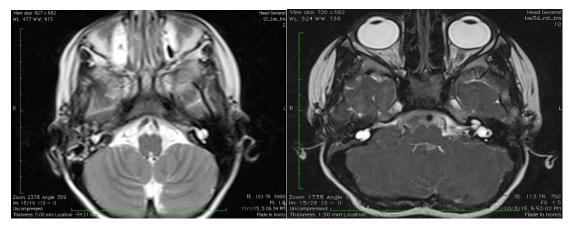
MRI axial section T2-weighted image showing bilateral common cavity anomaly Figure 4: MRI axial section 3D FIESTA showing right-sided common cavity deformity and left-sided incomplete partition
